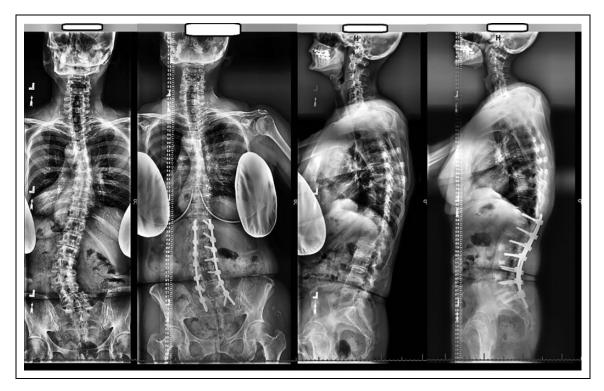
Preoperative and postoperative PA and lateral radiographs of a patient corrected with cMIS and demonstrating lucency of the S1 screws and possible pseudarthrosis at L5-S1.
